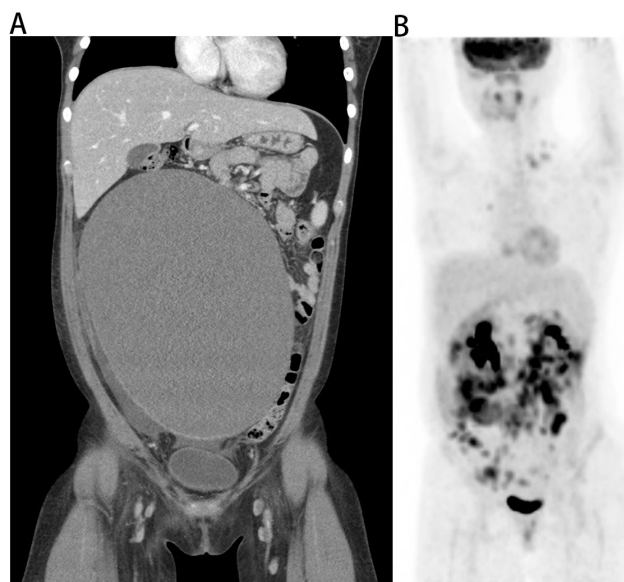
Radiologic findings, A. Abdominal-pelvis enhanced computed tomography. About 20 cm mass in right ovary. B. The positron emission tomography-computed tomography. No skeletal metastasis or parathyroid gland hyperplasia.
